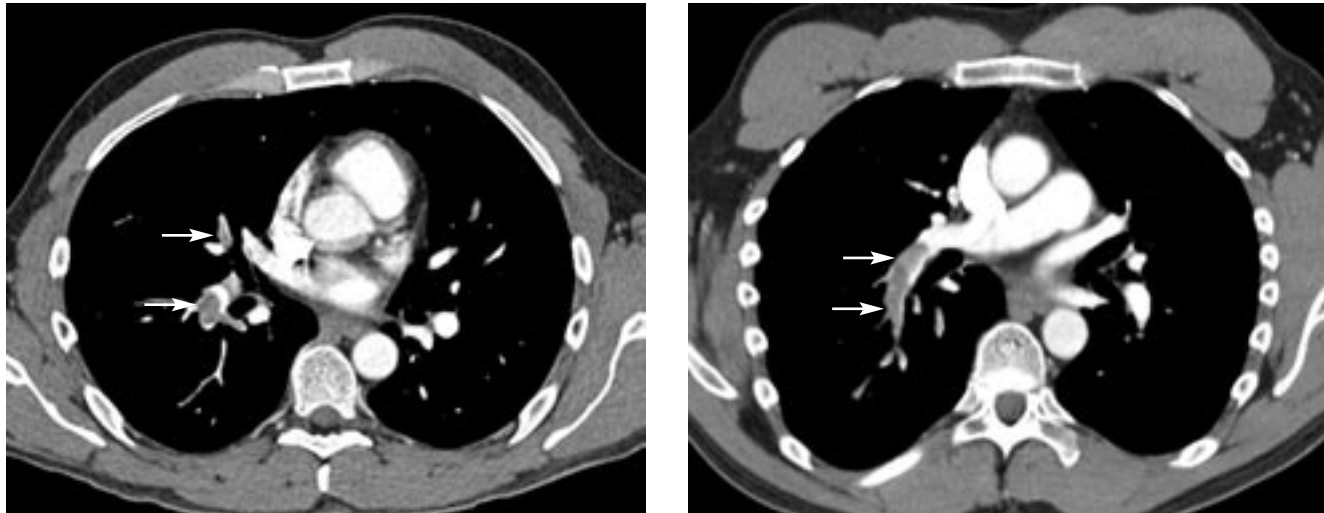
Left, axial image from a contrast-enhanced CT pulmonary angiogram shows central filling defects within the right descending pulmonary artery and right lower lobe and middle lobe lobar and segmental pulmonary arteries. Right, axial oblique reformation more accurately depicts the extent of thrombus in the right descending pulmonary artery.
